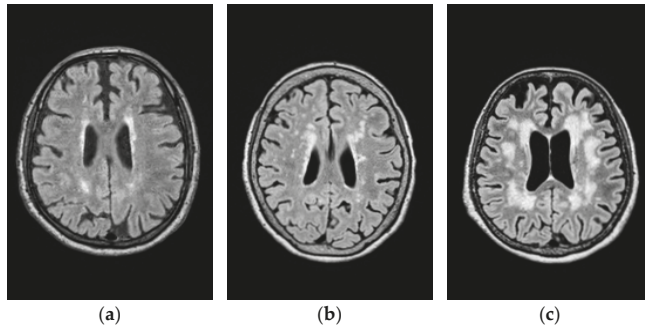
Lesion categorized by three grades of Fazekas shown in FLAIR images. (a) Fazekas grade 1; (b) Fazekas grade 2; (c) Fazekas grade 3
